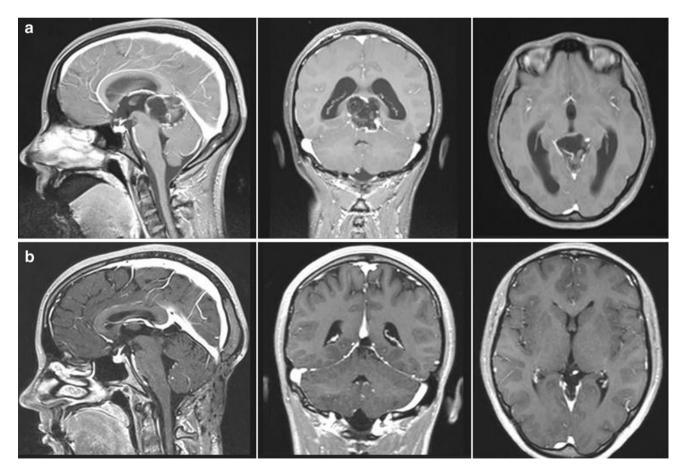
Preoperative a sagittal, coronal and axial contrast-enhanced T1-weighted MRI showing a pineal pilocytic astrocytoma. The follow-up contrast-enhanced T1-weighted MRI b shows no residual or recurrence 3 years later
